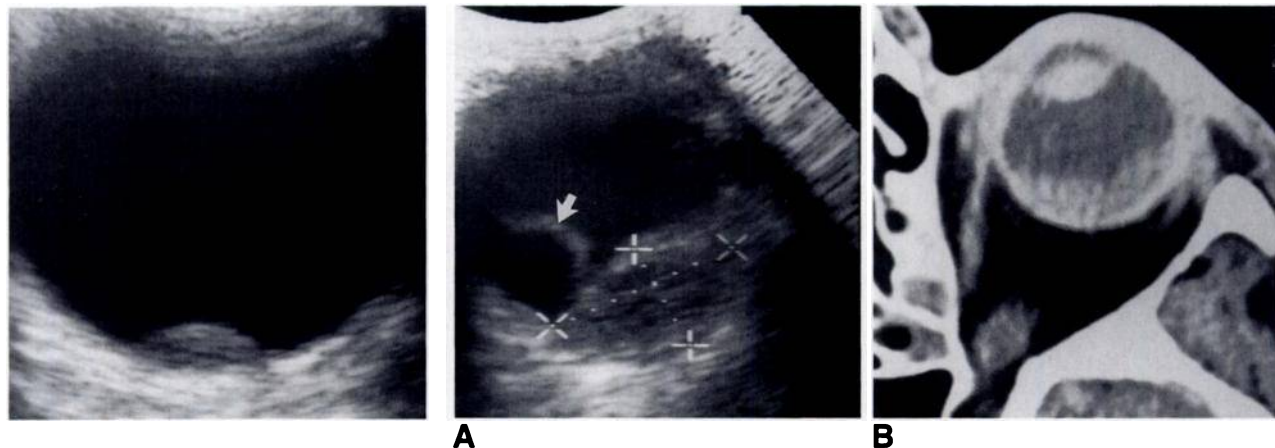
Small malignant melanoma. Axial sonogram shows small malignant melanoma on posterior of retina. Very small melanomas (2 mm in height) such as this one are best shown sonographically.
